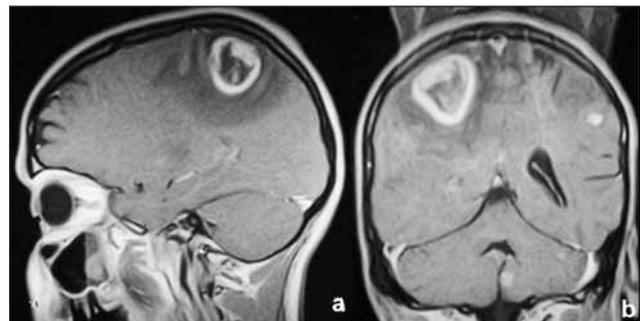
T1W MRI showing ring-enhanced mass lesion with IV gadolinium A) in the left occipital lobe B) in the right parietal lobe
